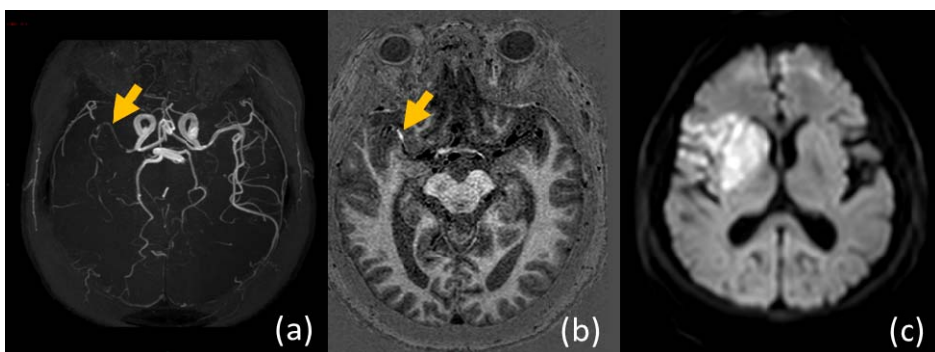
MR imaging of the brain in a 67 year old male patient. Both severe luminal stenosis on SNAP MRA view(a) and IPH on SNAP IPH view (b) in the right MCA were nicely delineated. DWI(c) shows the large acute infarction in right MCA territory.
